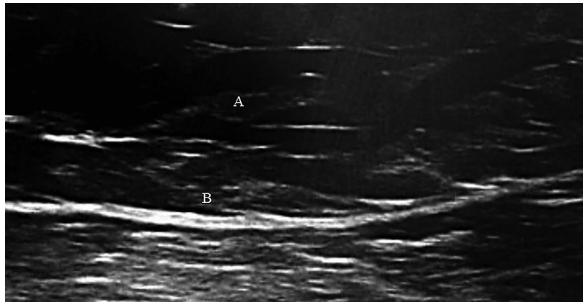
Ultrasound-guided tumescent injection. *A*, Soft tissue infiltration with spinal needle. *B*, Fascial border of adductor magnus muscle.
